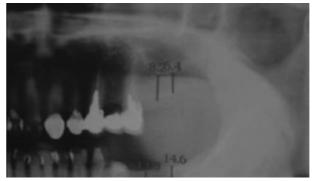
A. 63- year old female patient. Preoperative radiographic image explained that 8.2mm and 6.4mm of apicoocclusal dimension of alveolar bone was remained at left first and secondary axillary molar respectively.
